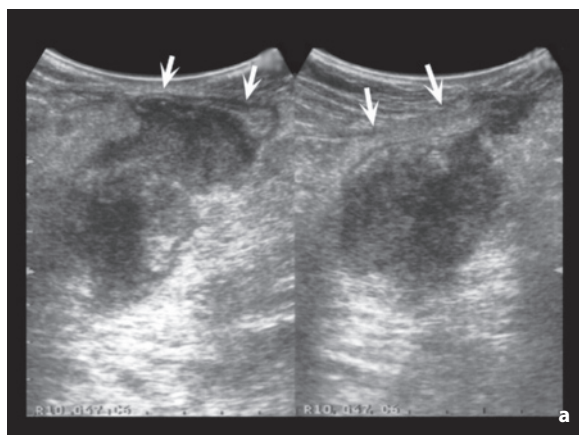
b Extra-adrenal pheochromocytoma. Para-aortic hypoechoic mass with poor vascular signals at CD (a). Coronal CT reconstruction shows moderate contrast enhancement of the mass (b, arrow)
